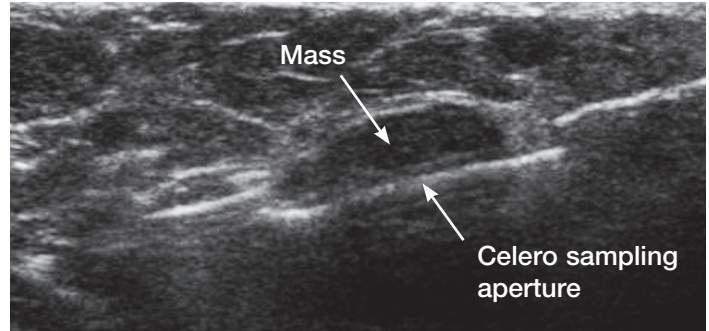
Ultrasound guided breast biopsy with the Celero handheld device using the pre-fire method for aperture confirmation
